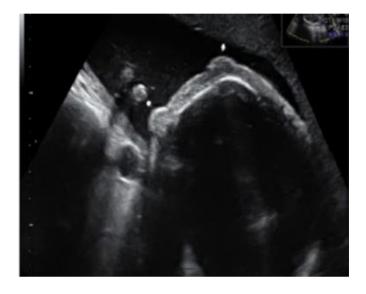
Two-dimensional ultrasonography – eyelid eversion of the fetus9.
